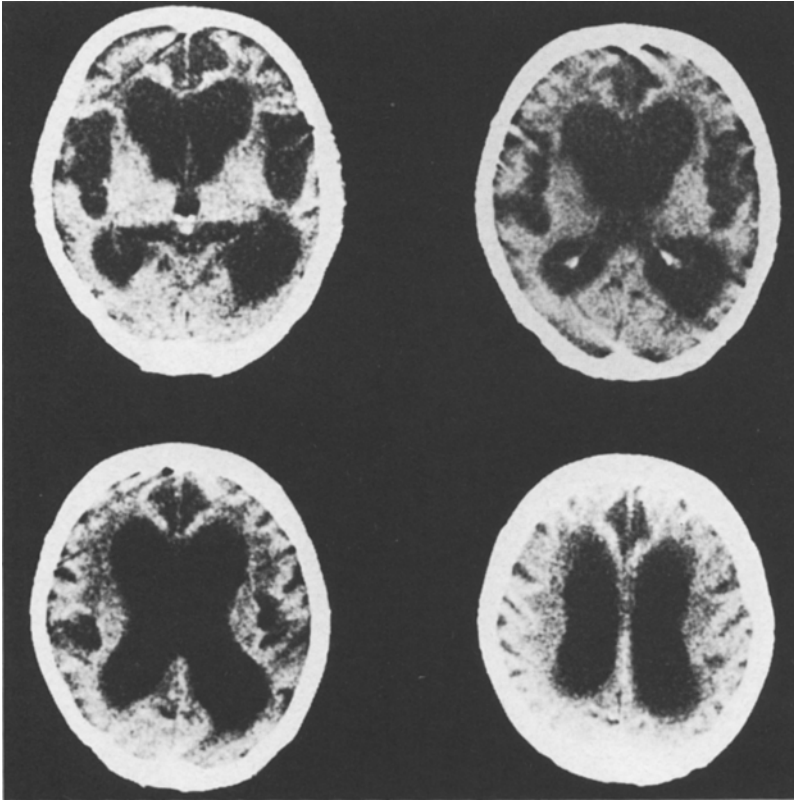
CT of a stage III patient
